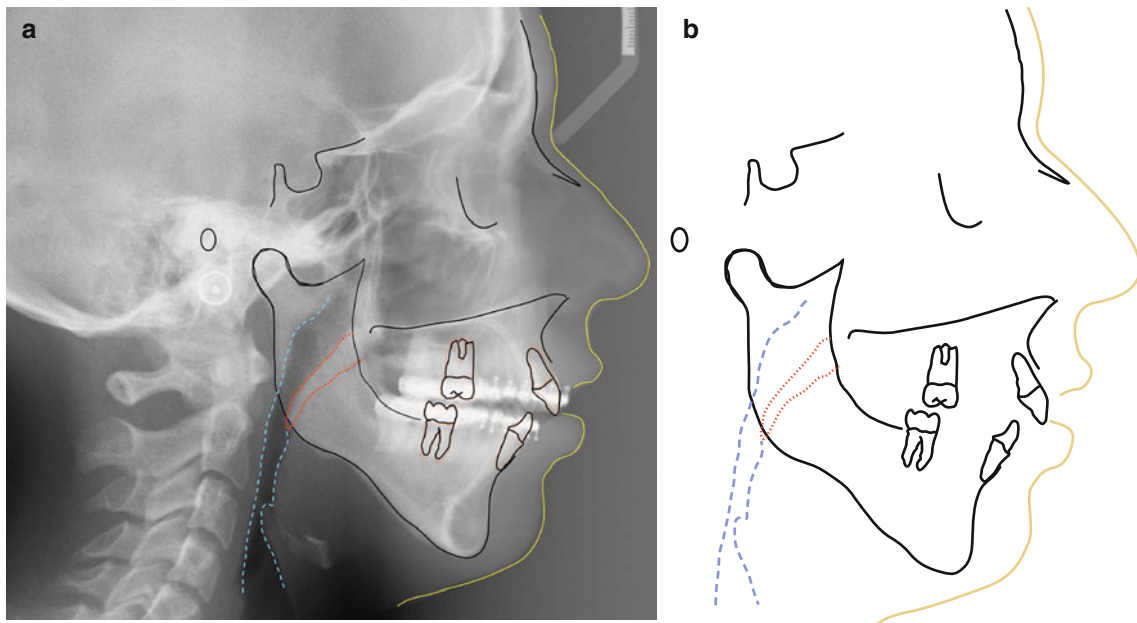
(a) Frosted acetate paper is placed on top of the radiograph and key structures are marked: skeletal, dentition, soft-tissue profile, airway and soft-palate. (b) The radiograph itself is no longer needed.
